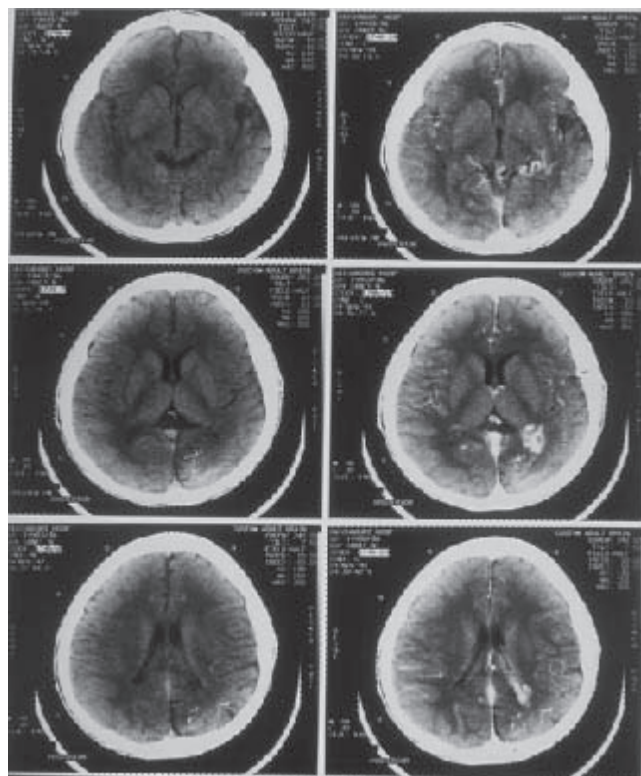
Computerized tomography (left-plain CT, right-contrast CT) demonstrated calvarial hemiatrophy, atrophy of parietal, temporal and occipital lobes, occipital gyral calcification, enlargement and increased enhancement of the glomus of the choroid plexus with prominent subependymal veins on the left side.
